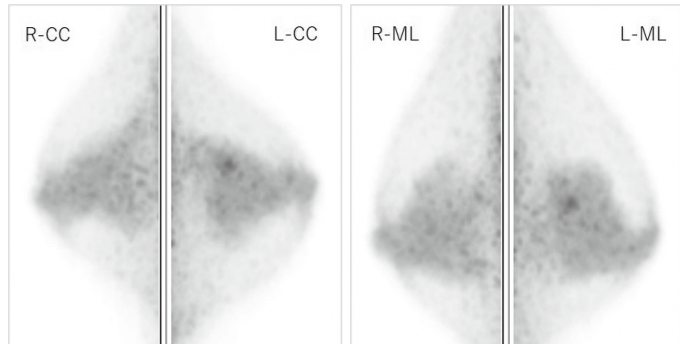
False Negative Case (Breast Cancer with Reduced FDG Uptake in Late Phase)
